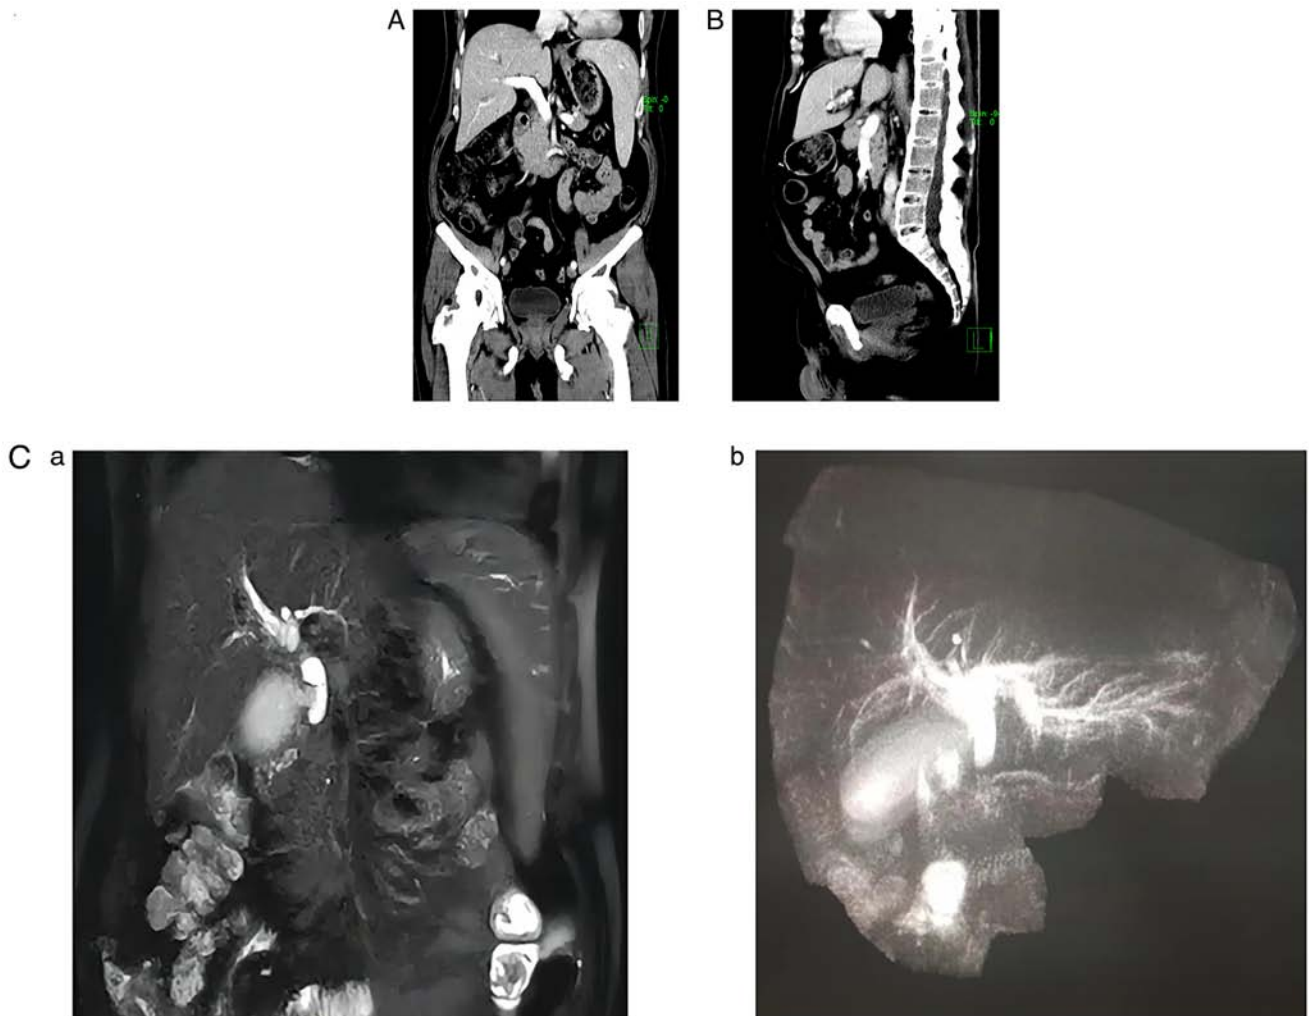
(A and B) Observations from enhanced computed tomography scan of the whole abdomen. (A) The intrahepatic and extrahepatic bile ducts were dilated, and distal common bile duct stones were suspected. (B) Enlarged gallbladder indicative of possible cholecystitis. (C-a and C-b) Observations of magnetic resonance cholangiopancreatography. (C-a) Middle and lower segments of the common bile duct were resected for unknown reasons. Atrophy of the left kidney, lymph nodes at the posterior edge of the pancreatic head and bilateral renal cysts. (C-b) Gallbladder enlargement and cholecystitis.
